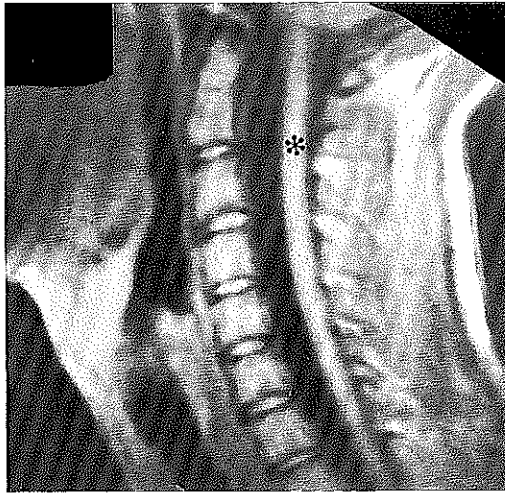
T1-weighted sagittal image of a normal cervical spine. The spinal cord (*) is clearly visualized within the low-signal intensity spinal fluid.
